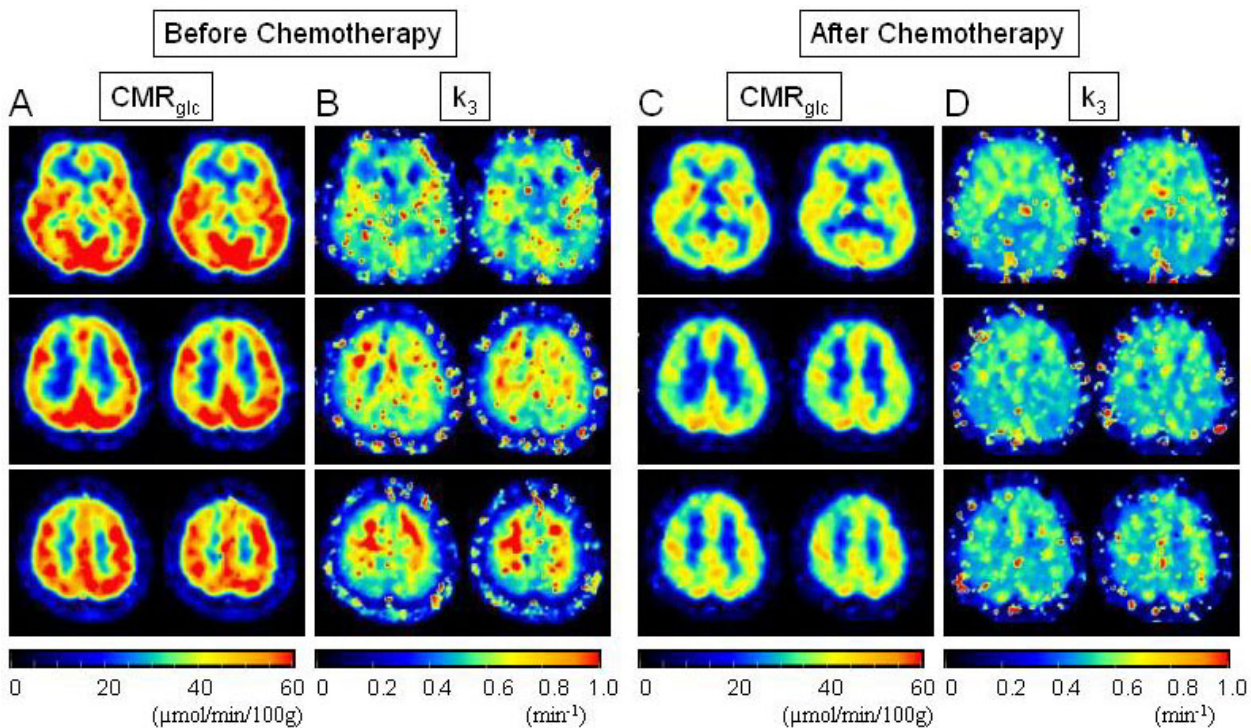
[^{18}F]FDG-PET images with kinetic analysis obtained before (A, B) and after (C, D) chemotherapy. (A) The images do not display a significant increase in FDG uptake (CMR_{glc}) in the bilateral frontal and parietal white matter. (B) Kinetic analysis of this scan shows markedly increased hexokinase activity (k_3) in the lesions compared with the unaffected occipital white matter. After chemotherapy, FDG uptake in the cortex is reduced globally compared with that observed in the initial [^{18}F]FDG-PET images (C) and kinetic analysis of this scan shows decreased hexokinase activity (k_3) in the lesions (D).
